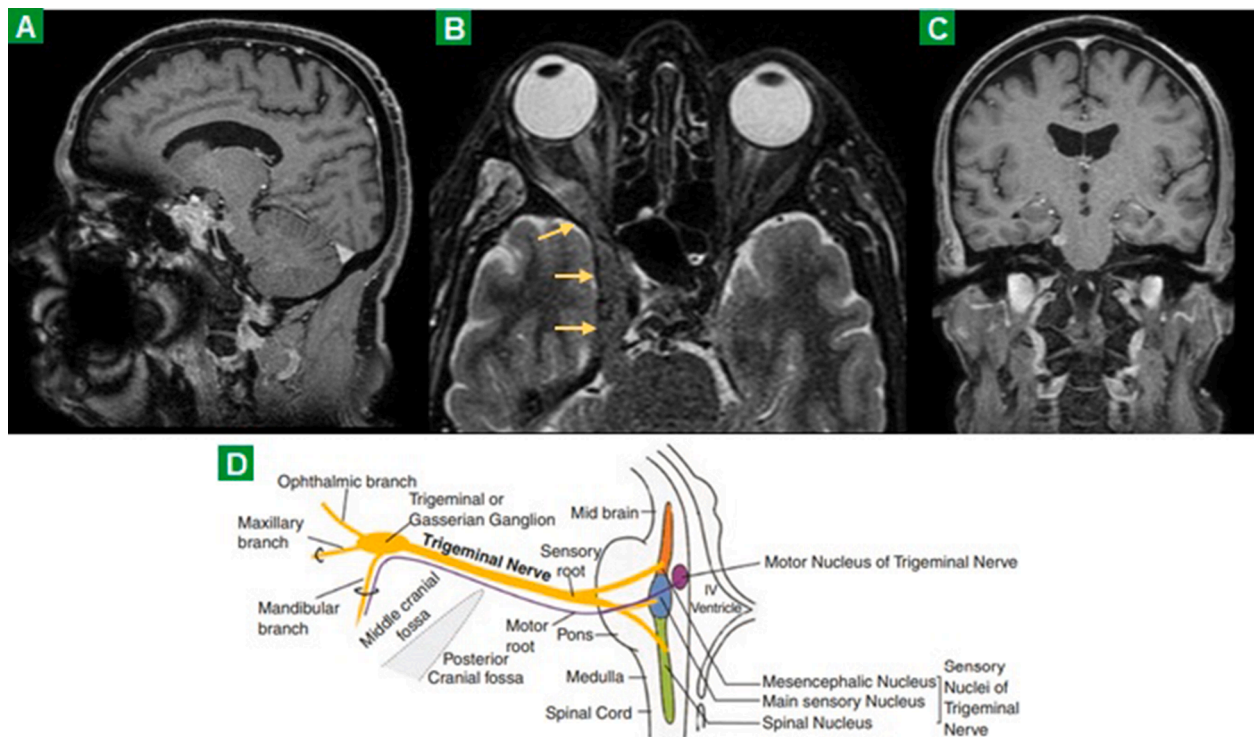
MRI skull and orbits. (A) Sagittal T1-weighted gadolinium-enhanced section showing an expansile mass in the right orbital apex with irregular invasion into the preoptine cistern. (B) Axial T2 STIR section: arrows identifying an infiltrative lesion of the trigeminal nerve in the orbital apex transition, Meckel's cave, cavernous sinus, and trigeminal root emerging from the anterior pons. (C) Coronal T1-weighted gadolinium-enhanced section revealing involvement of the trigeminal nerve root on the right at its origin in the pons. (D) Anatomy of the trigeminal nerve to emphasize the path outlined in figures A, B, and C. Adapted from Singh GP. (2019). Anatomy of Trigeminal Nerve. Handbook of Trigeminal Neuralgia, 11–22. https://doi.org/10.1007/978-981-13-2333-1_2.
